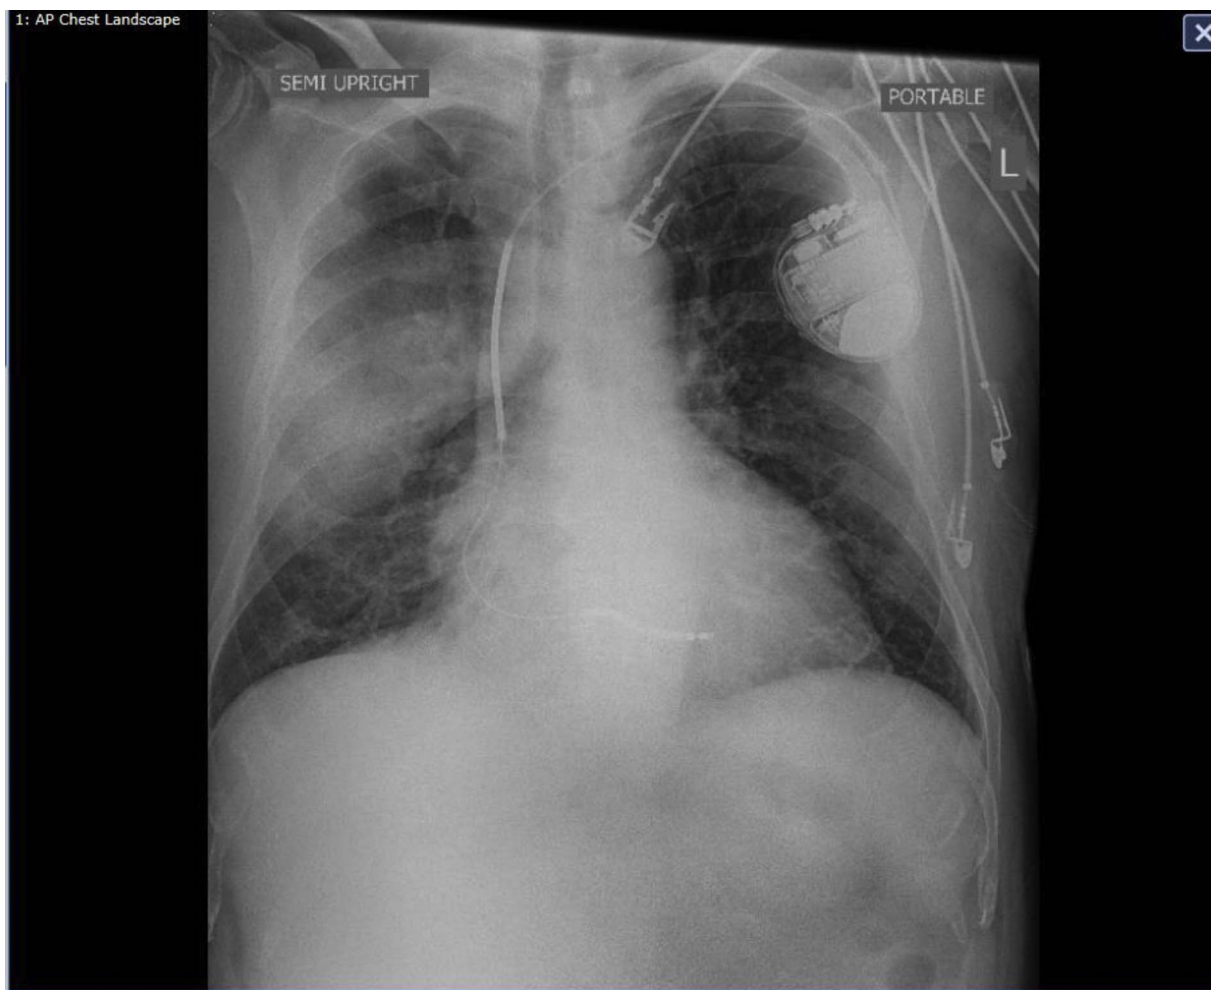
Chest radiograph taken on admission at the outside hospital.
